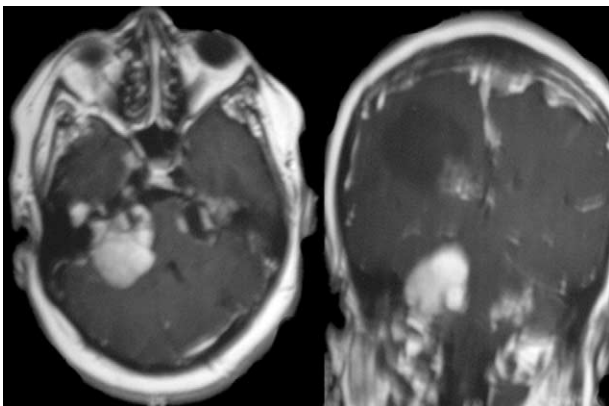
Preoperative T1-weighted MRI scans with gadolinium of patient 1. Left: Axial image showing bilateral acoustic neuromas, the right larger than the left. Right: Coronal image showing left frontal bone dysplasia, en plaque meningioma, right frontal cystic lesion, and left cerebellar lesions.
